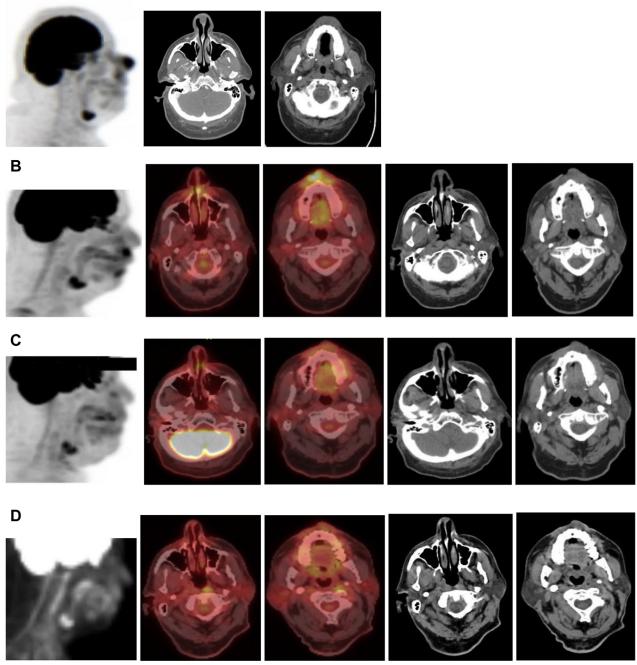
Fluorodeoxyglucose-positron emission tomography (PET), computed tomography (CT), and fused PET/CT scans showing microcystic adnexal carcinoma lesion of the nose and philtrum at (A) 1 month before chemoradiotherapy and response to treatment at (B) 3 months, (C) 6 months, and (D) 1 year after chemoradiotherapy. A fused PET-CT image was not available for the pretreatment scan.
